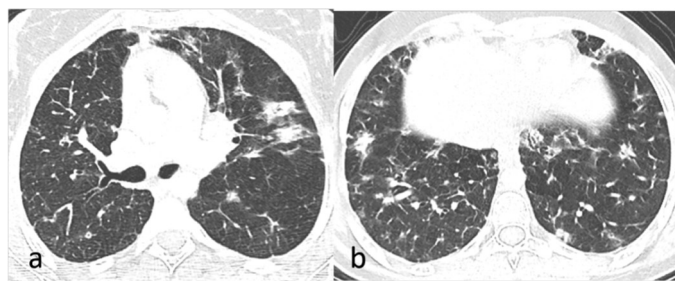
15-year-old girl with primary immunodeficiency (LPS-responsive beige-like anchor protein deficiency). Chest computed tomography images (a, b) show multiple irregular nodular opacities, ground-glass opacities, interseptal thickenings, and focal hyperaeration areas.
